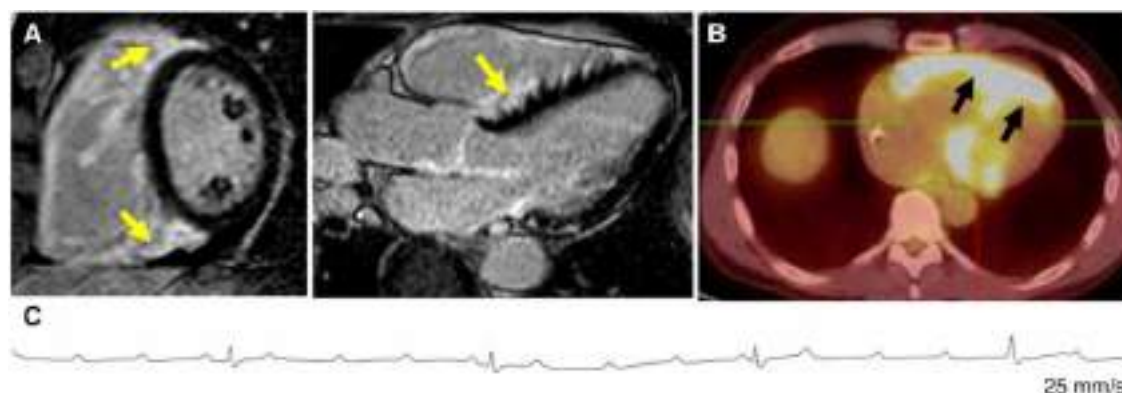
CMR (A) demonstrating septal and right ventricular late gadolinium enhancement (LGE); FDG-PET (B) showing extensive myocardial inflammation (arrows) and mediastinal/hilar lymph node uptake, consistent with cardiac sarcoidosis presenting with high-degree AV block (C).
